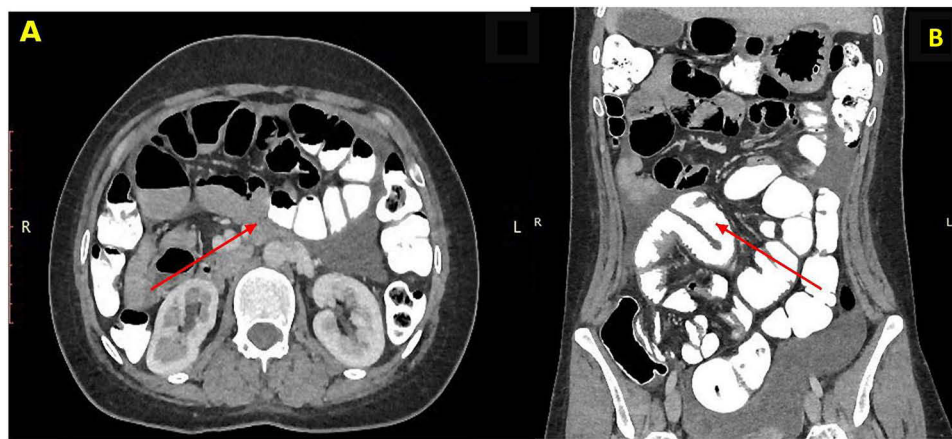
Repeat CT scan performed with oral, intravenous, and rectal contrast, identifying two discrete strictures (arrows) of approximately 3 cm each, located in the mid-ileum and terminal ileum. (A) Axial view. (B) Coronal reconstruction.
